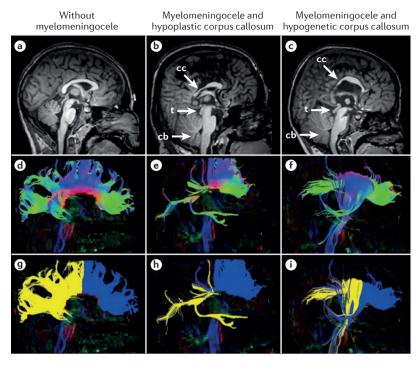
MRI appearance of brain dysmorphology in myelomeningocele. Mid-sagittal MRI images of a typically developing child (parts a, d and g), a child with myelomeningocele and a hypoplastic corpus callosum (parts b, e and h) and a child with myelomeningocele and a hypogenetic corpus callosum (parts c, f and i). T1-weighted MRI images (parts a-c) that reveal a downward shift of the cerebellum (cb) in the children with spina bifida, representing the Chiari II malformation. Also note the tectal beaking (t) and the structural abnormalities in the corpus callosum (cc). Diffusion imaging tractography (parts d-i) showing connectivity emanating from the corpus callosum. This connectivity is divided into anterior (frontal; blue) and posterior (yellow) segments (parts g-i). Note the relative preservation of frontal connectivity in the individuals with spina bifida. There is a greater and more aberrant pattern of connectivity in the child with the hypogenetic corpus callosum. Images courtesy of K. Bradley (University of Houston, Texas, USA) and J. Juranek (University of Texas Health Science Center at Houston, USA).
